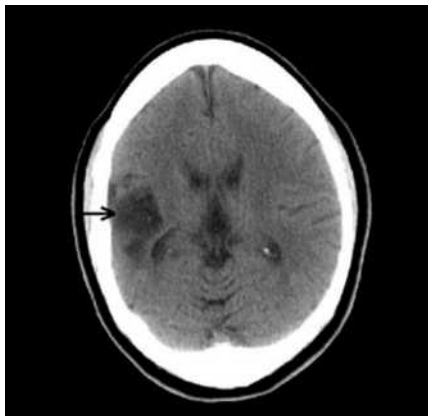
CT scan, axial section of the brain showing a right middle cerebral artery infarct limited to the right temporal lobe.
